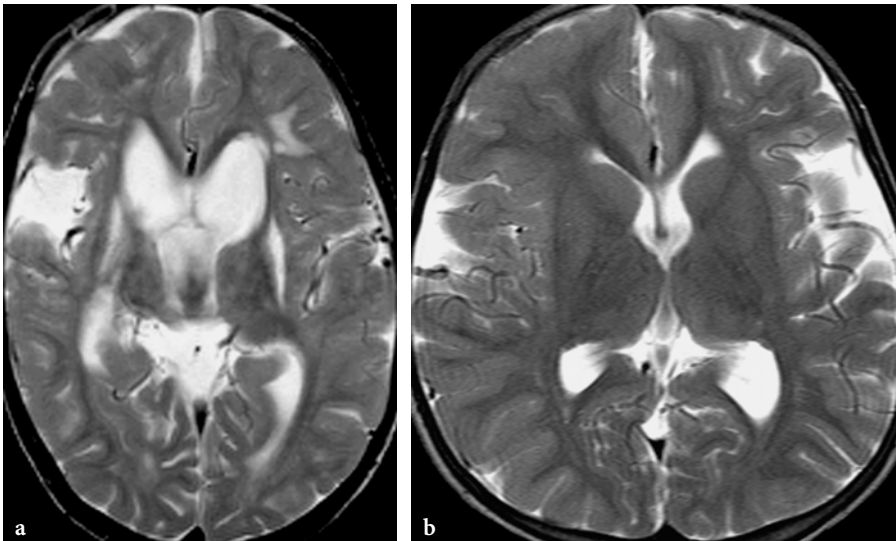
MR imaging findings in patients with glutaric aciduria type 1 (riboflavin dependent clinical phenotype). a Axial T2-weighted fast spin-echo image in a 7-year-old male patient diagnosed with glutaric aciduria type 1 only in childhood, when he already had severe extrapyramidal movement disorder. The image shows severe bilateral, basal ganglia lesions as well as patchy white matter lesion. The open operculum sign is present only on the right side. b Axial T2-weighted fast spin-echo image in the cousin of the previous patient at the age of 5 years. He was diagnosed to have the disease by neonatal screening and received appropriate care immediately. Although his psychomotor development was normal, he was macrocephalic and the image shows typical bilateral open opercula
